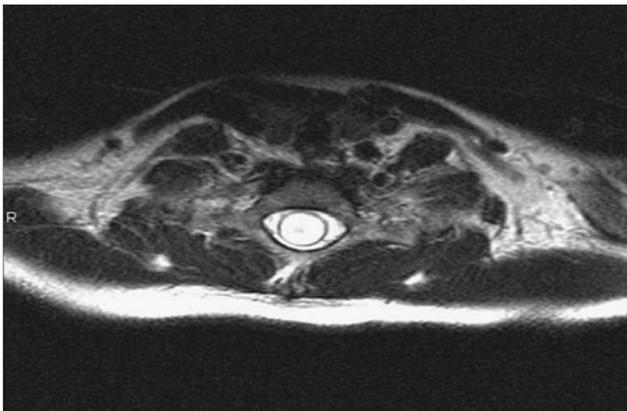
Axial magnetic resonance image through the cervical portion of a holocord syrinx in a young girl. Note the extremely thin nature of the spinal cord. This patient surprisingly had very little symptomatology and presented with scoliosis.
